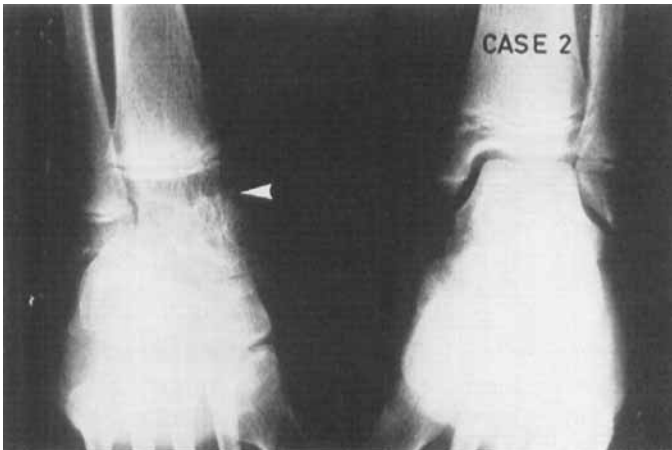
Case 2. Antero-posterior radiograph of both ankle joints showing bony fusion of the right ankle joint. Site of previous right ankle is level with lower fibular epiphyseal plate.
